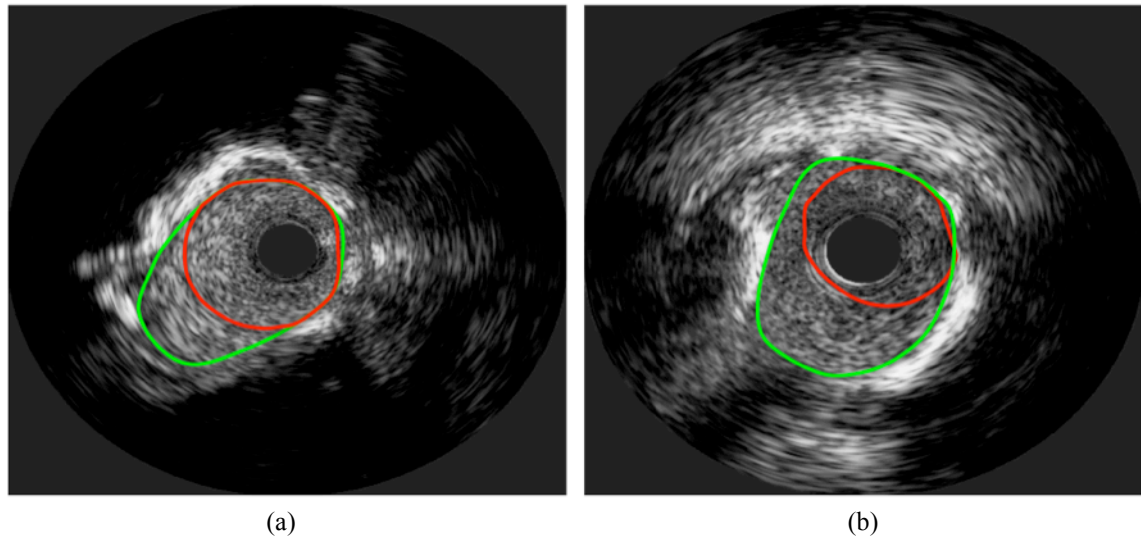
Two examples where the algorithm fails to correctly identify lumen borders. An eccentric artery with deep shadow (a), repetitive reflection of ultrasound signals (ring-down artifact) from surface of transducer's element (b).
